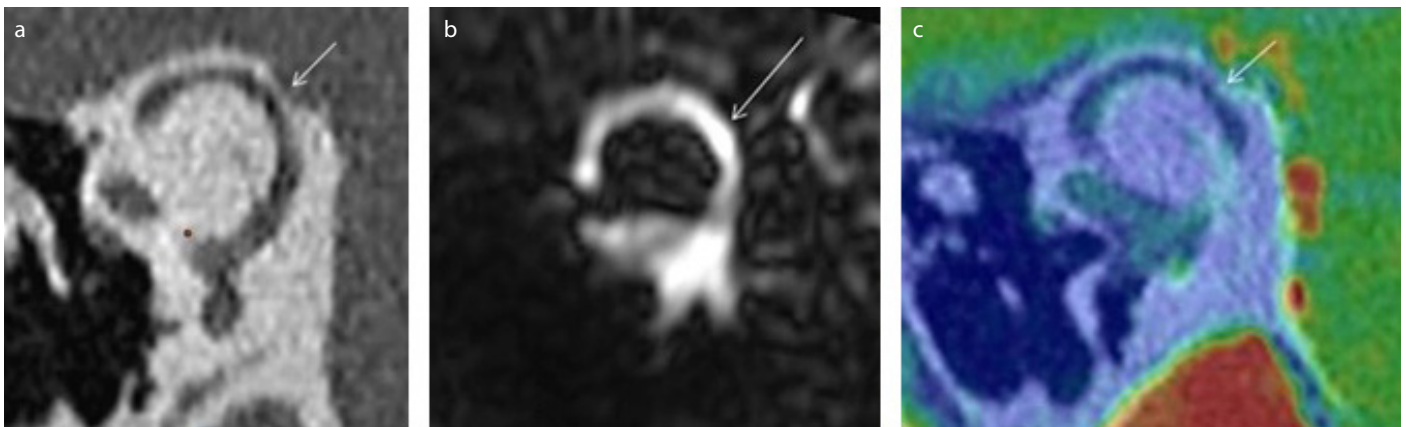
a-c. Case report 1 – Class A. a) right ear high-resolution computed tomography (HRCT) Pöschl plane. “Cookie bite” corresponding to a “near dehiscence”; a thin bone covering the membranous SSC is observed (white arrow). b) T2 HR DRIVE; superior semicircular canal (SSC) membrane in Pöschl plane. and c) Fusion between HRCT and 3D T1 weighted enhanced sequences. b) and c) images show no contact between the membranous SSC and superior petrosal sinus (SPS). Arrows indicate the SPS at a distance from the membranous SSC with no contact between the two structures.
